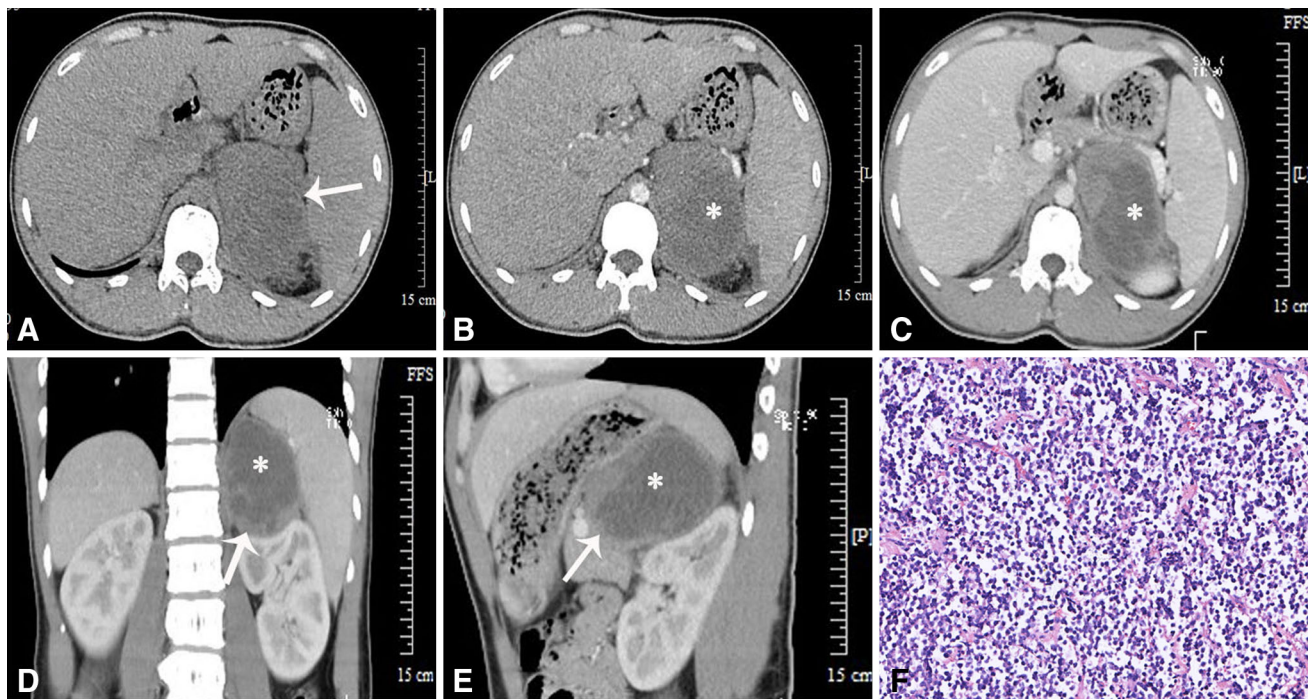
An adrenal PNET in a 22-year-old man (case 5) (a–e). An unenhanced CT scan showed a well-defined oval mass in the region of the left adrenal gland. The mass showed mild heterogeneous
